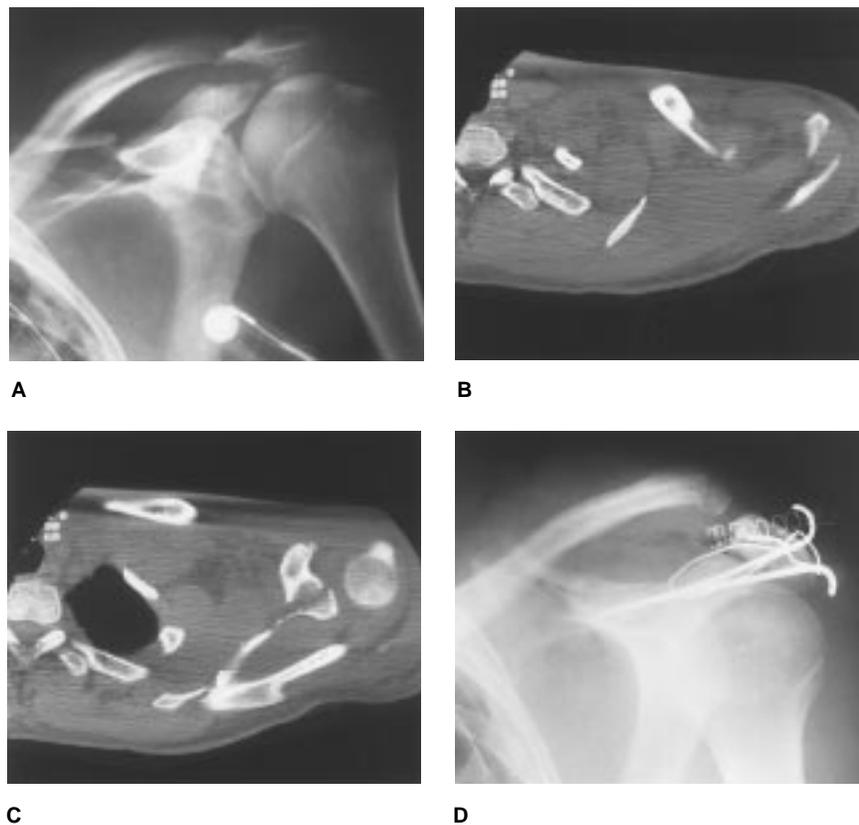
Images of a patient who sustained fractures of both the coracoid and the acromial processes. A, Preoperative AP radiograph of the involved area. B, Axial CT image of the acromion. Note the wide separation between the acromial fragments due to the associated coracoid process fracture. C, Axial CT image shows the fractured coracoid process. D, AP radiograph of the shoulder after ORIF of the acromial fracture using the dorsal tension-band technique.
